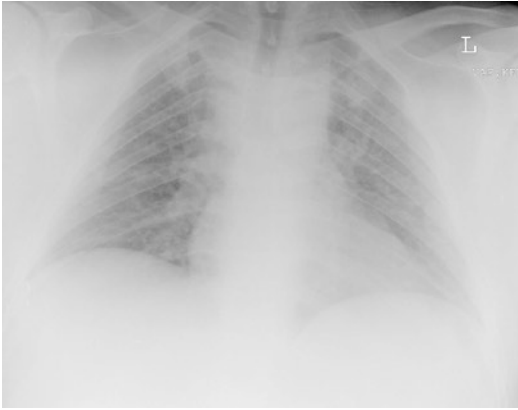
A 35-year-old man with varicella virus infection: chest radiograph showing multiple fleeting 5–10 mm miliumary nodules in both lungs
